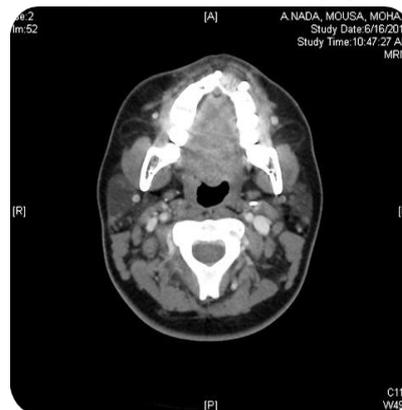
Head CT scan (Axial view) showing maxillary lesion with small growth 3 mm
